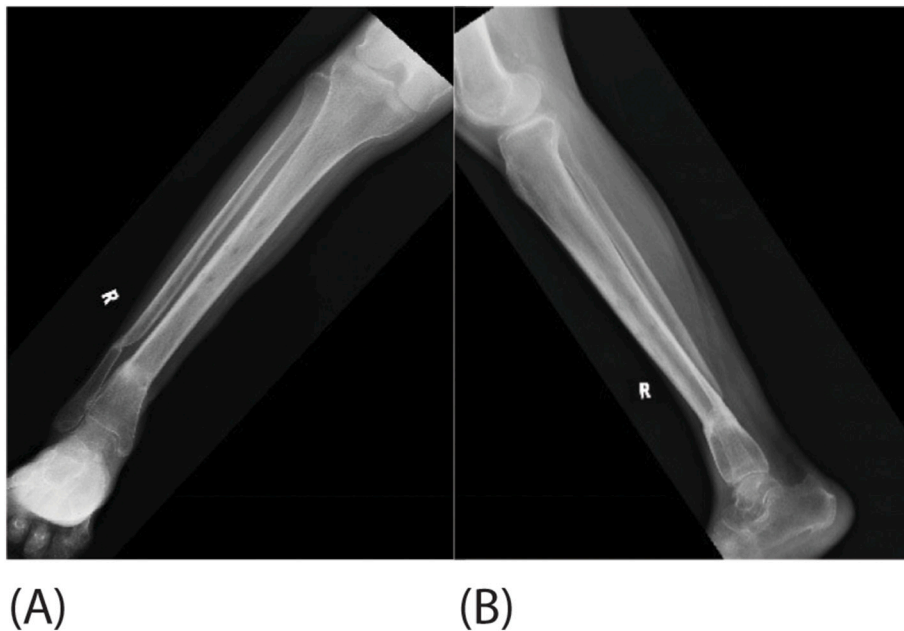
(A) Anterior Posterior Radiograph of right leg 1 year post removal of Ilizarov external fixator. (B) Lateral Radiograph of right leg 1 year post removal of Ilizarov external fixator.
